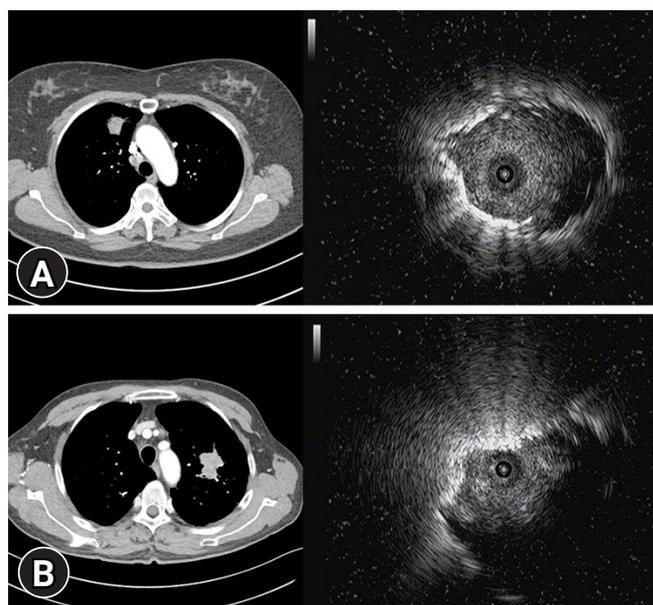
Axial images of chest computed tomography and the ultrasound images associated with the probe location of radial probe-endobronchial ultrasound. (A) Within the lesion. (B) Adjacent to the lesion.
